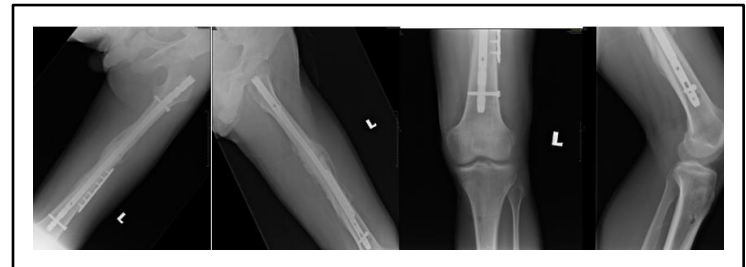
X-rays post removal of distal most locking screw
